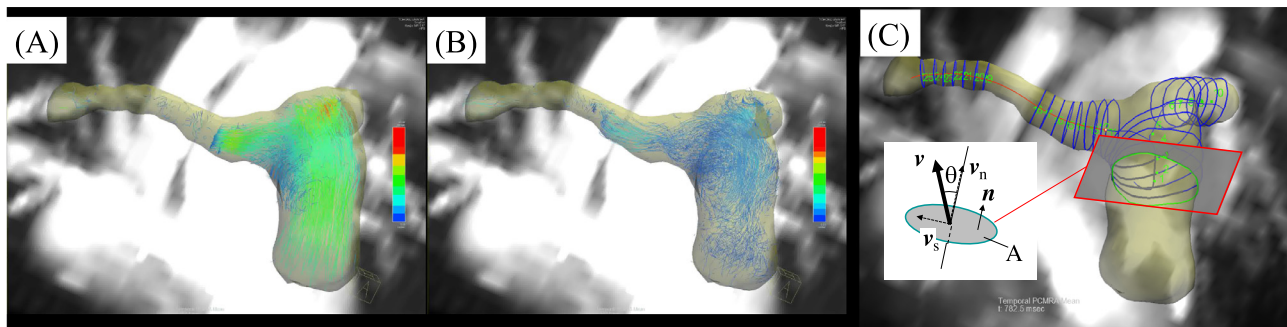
Flow streamlines of the pulmonary artery before intervention in the systole (A) and diastole (B) periods. Assessment of the pulmonary arterial blood flow by 4D-flow MRI (C). Planes in the pulmonary arteries were set to evaluate the volume flow rate. The axial direction of the aorta was defined as the normal direction of the plane. Volume flow rate (Q) was calculated as $Q = \sum^{N_p} \int v_n dA / N_p$, where N_p indicates the number of phases of 4D-flow MRI, v is the spatial averaged velocity vector in each plane, n is the normal unit vector of the plane, v_n is a normal component of v (ie, $v_n = v \cdot n$), and A is the cross-sectional area.
